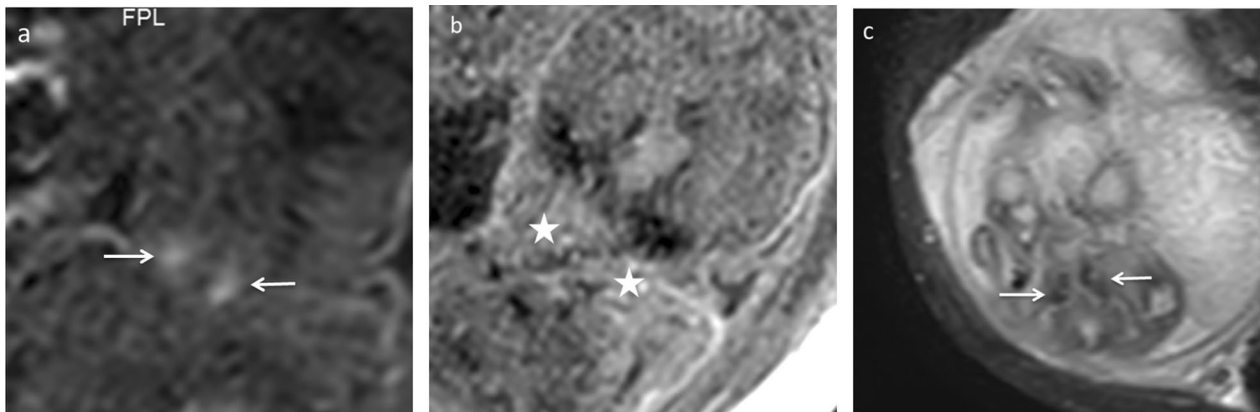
(a) T1-weighted coronal image of fetal MRI (1.5 T) at the level of head and neck in a normal fetus shows normal T1 hyperintense signal in both lobes of thyroid gland (white arrows). (b) T1-weighted coronal image of our present case shows loss of normal hyperintensity in the region of thyroid gland (white stars). (c) T2* weighted coronal image of fetal MRI shows hypointense signal in the region of thyroid gland (white arrows)
